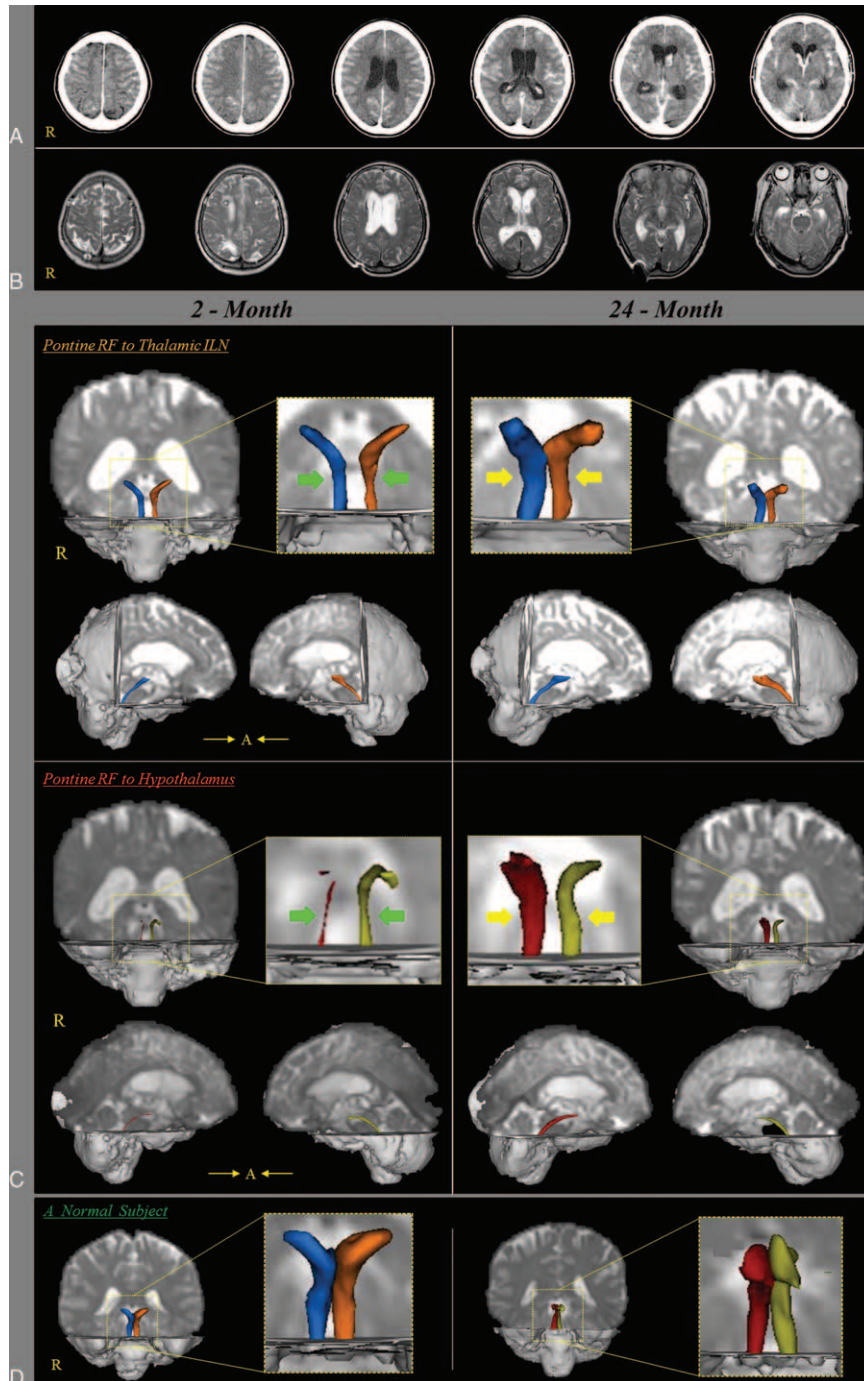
(A) Brain CT images at onset show a subarachnoid hemorrhage and intraventricular hemorrhage and hydrocephalus. (B) Brain MR images at 2 months after onset show a leukomalactic lesion in both fronto-parietal lobes. (C) Results of diffusion tensor tractography (DTT) for both lower dorsal and ventral ascending reticular activating system (ARAS). On 2-month DTT, narrowing (arrows) of both lower dorsal and ventral ARASs was observed on both sides: in particular, among 4 neural tracts of the lower ARAS, the right lower ventral ARAS was narrowest. By contrast, on 24-month DTT, the 4 narrowed neural tracts of both lower dorsal and ventral ARASs were thickened compared with those of 2-month DTT (arrows). (D) DTTs of the lower dorsal and ventral lower ARAS of a normal subject (65-year-old woman). ARAS = ascending reticular activating system, CT = computed tomography, DTT = diffusion tensor tractography, MR = magnetic resonance.
